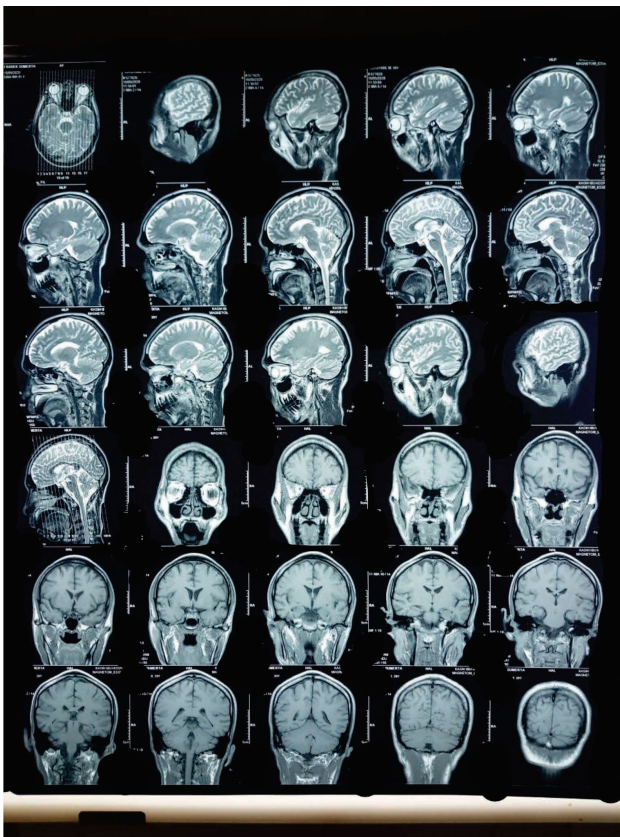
MRI of head evaluation 6 months after treatment shows normal
